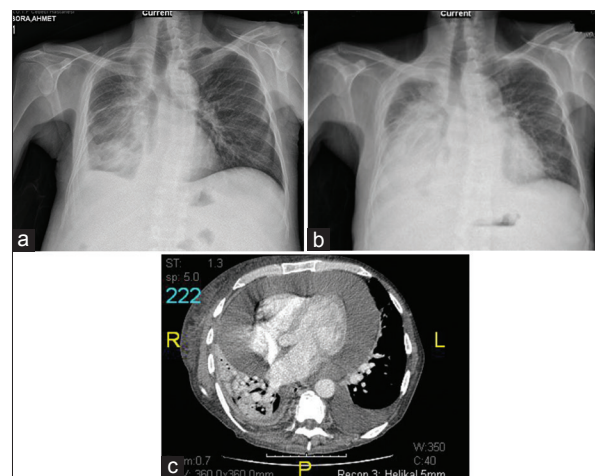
Chest X-ray graph of patient before procedure (a), and after procedure (b), thorax computed tomography examination after Sm-153 treatment (c)
